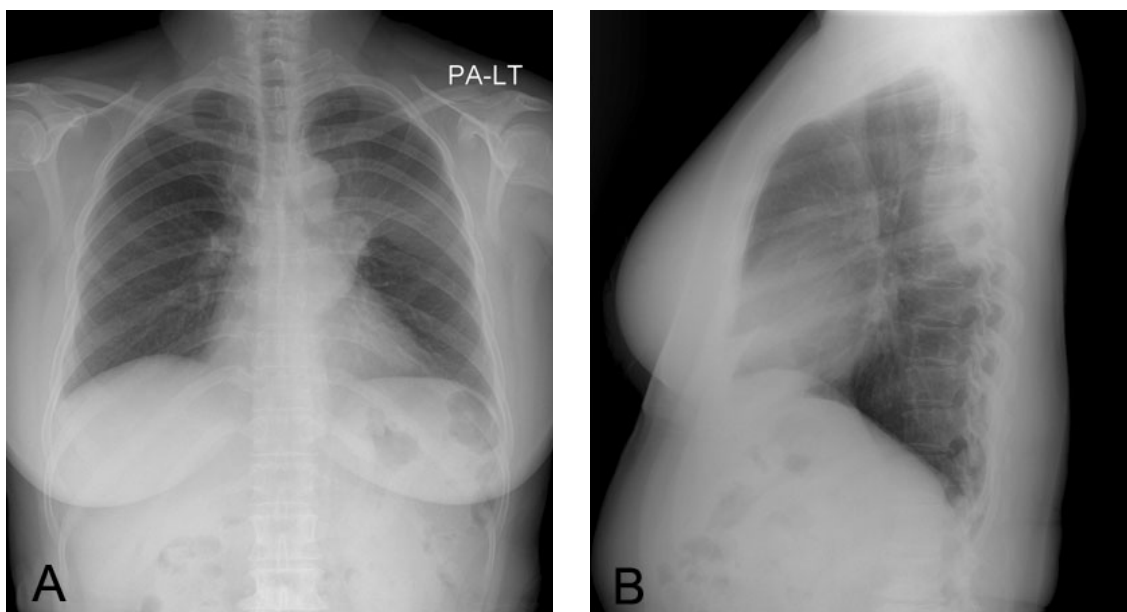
Chest PA (A) and lateral radiograph (B) shows well-margined mass in apicoposterior portion of left hemithorax.
